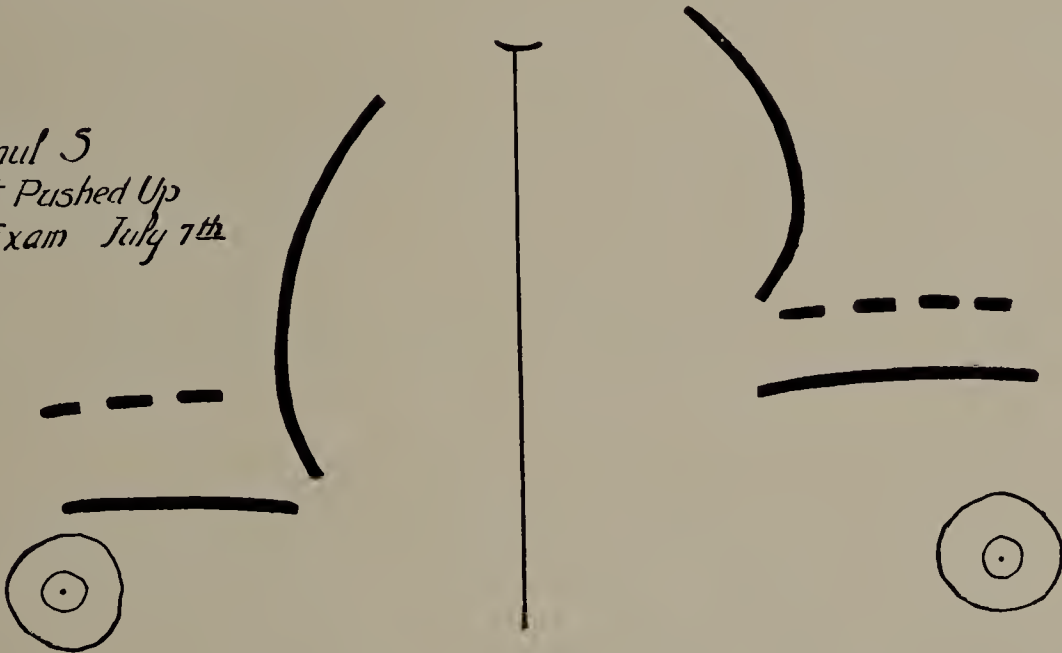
Paul S. July 7. Cut of tracing from first X-ray examination. (Cut one-third life size.)
